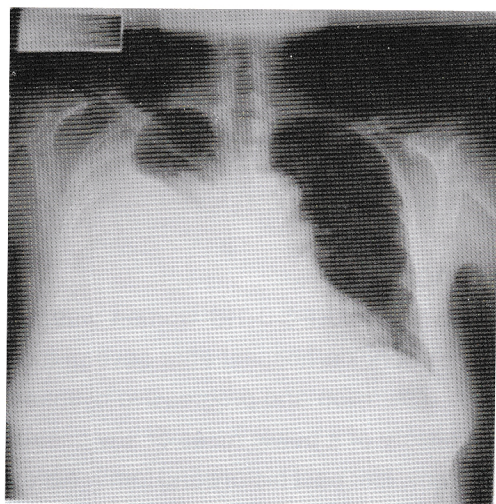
Chest X-ray shows large right pleural effusion 2 days before surgery.
